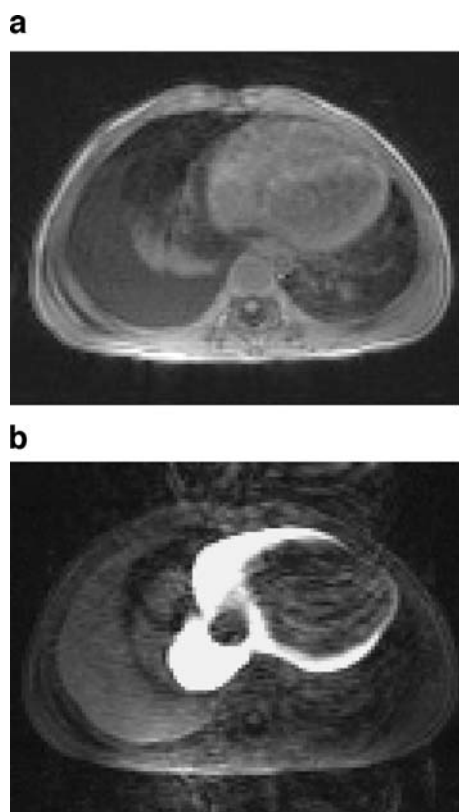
a Transversal T1-weighted gradient echo (GRE) image before infusion of PD fluid, showing a large pleural effusion in the right dorsal lung. b After infusion of PD fluid containing gadolinium, selective enhancement of the pericardial effusion was demonstrated, whereas the pleural effusion in the right dorsal lung was not enhanced
